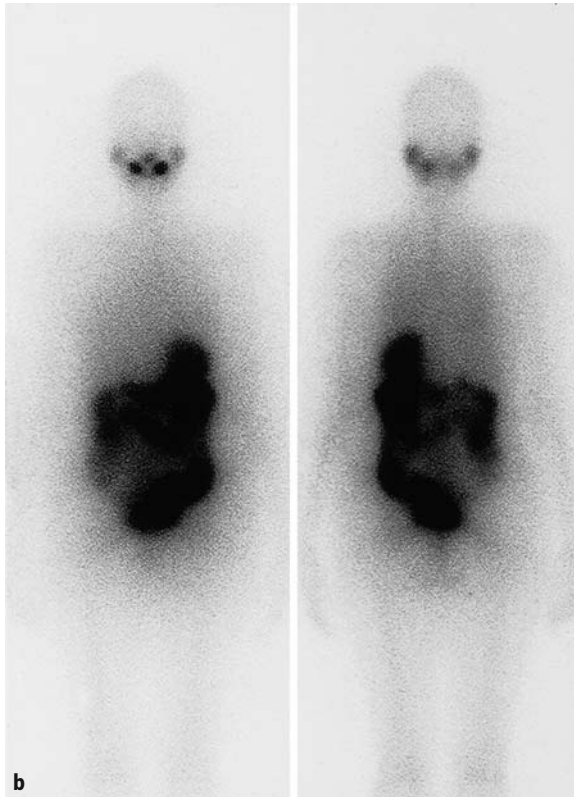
b. The second ¹³¹I whole-body scintigraphy (7.4 GBq ¹³¹I) demonstrated complete remission 3 months later
